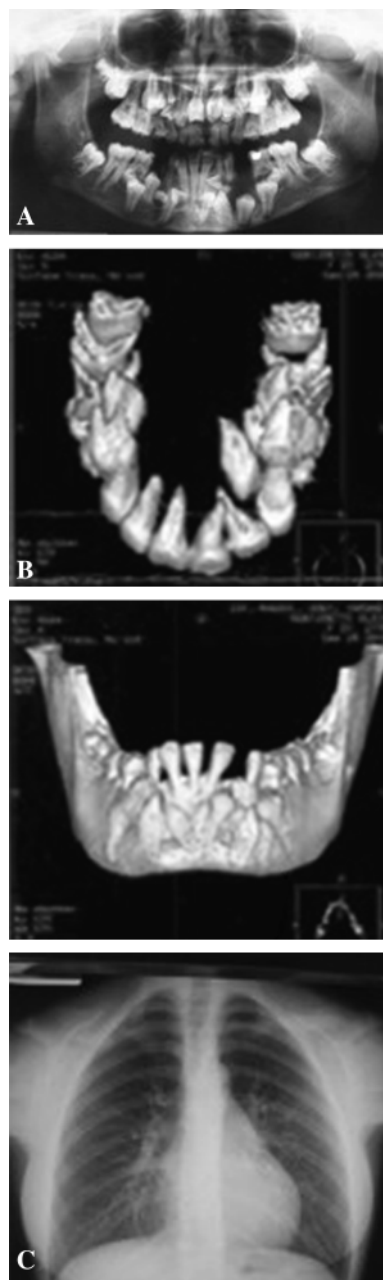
(A) Panorex radiograph. (B) Three-dimensional computed tomographic reconstruction. (C) Chest radiograph of the index case.
